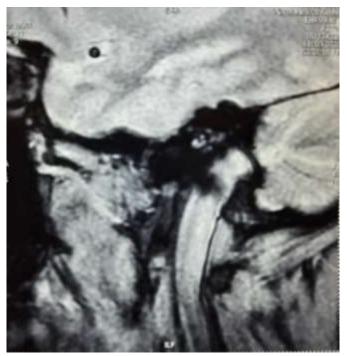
MRI showing mild flattening of condyle noted on right side
